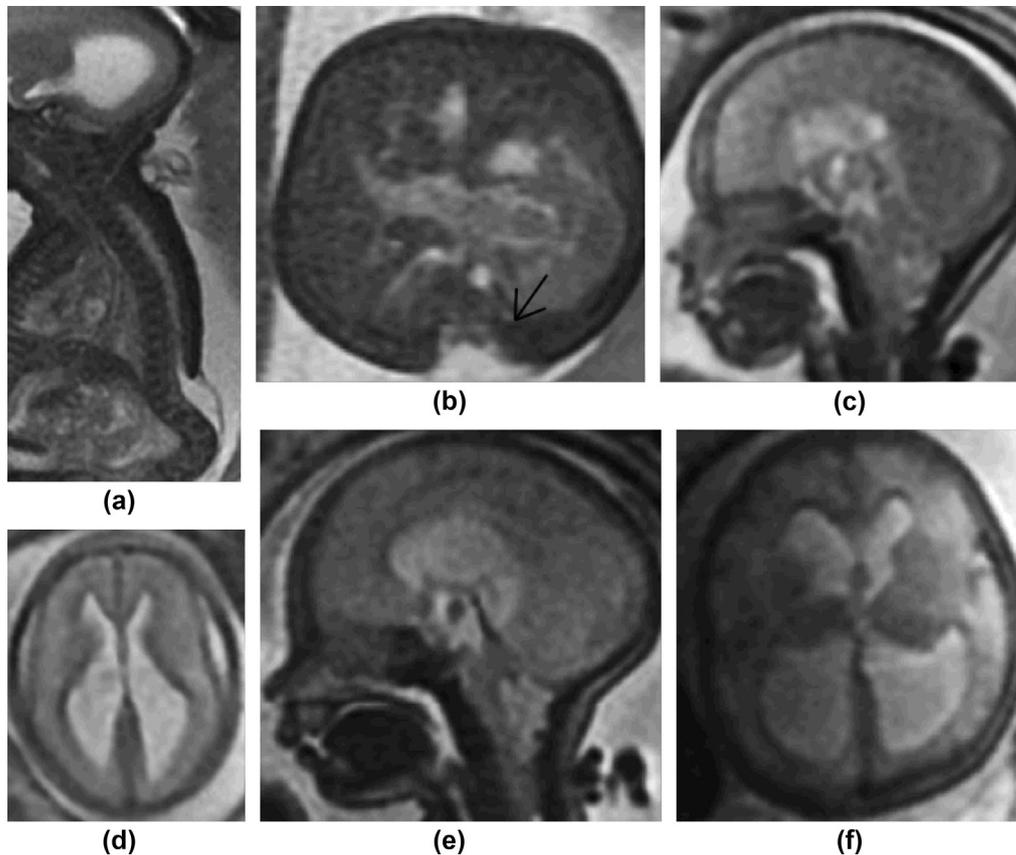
iuMRI images of a fetus with a myelomeningocele and Ch2 malformation at (a–c) 22 weeks and at (d–f) 31 weeks. (a,b) Sagittal and axial imaging of the spine show the open spinal dysraphism (marked with an arrow on axial imaging). (c) Sagittal imaging of the brain shows relatively minor descent of the cerebellar vermis below the foramen magnum and no T2-weighted signal abnormality in the vermis at 22 weeks, whereas at 31 weeks there is marked descent of the vermis and abnormal T2-weighted signal (e). (d,f) There was progressive VM and increasing effacement of the external CSF spaces.
